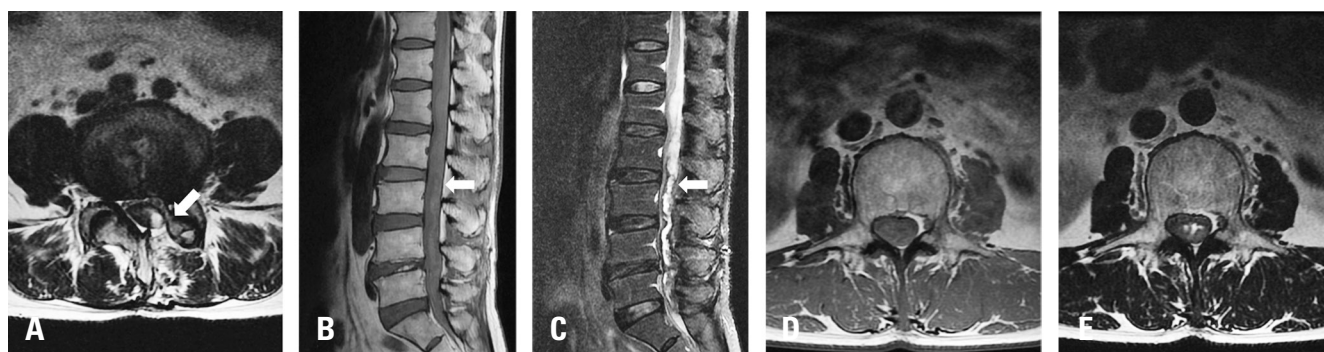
Lumbar spine magnetic resonance images. (A) Axial images showing previous left hemilaminectomy at the L4-5 level and high signal intensity in the dorsal aspect of the intradural space on T2-weighted images. (B) T1-weighted sagittal image showed intermediate signal intensity and (C) T2-weighted sagittal image showing high signal intensity suggestive of hyperacute subdural hematoma extending from the 11th thoracic level to the first sacral level. Axial view. (D) T1-weighted axial image and (E) T2-weighted axial image at the L3-4 level.
